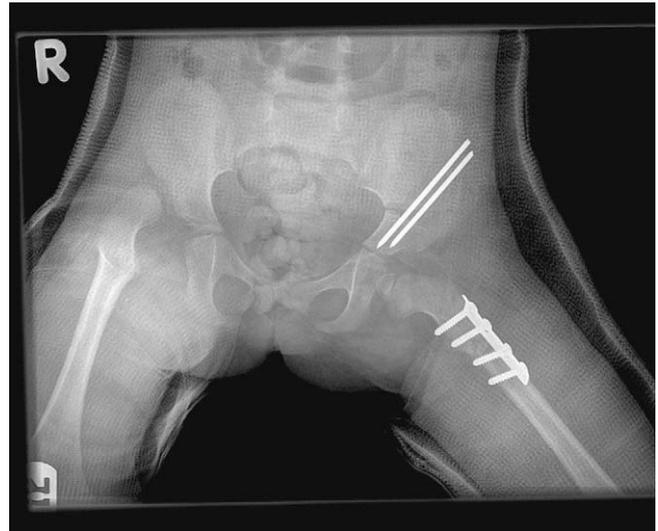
Post operative radiograph in a hip spica following open reduction, innominate osteotomy and shortening femoral osteotomy. Note: Staging of bilateral procedures.
